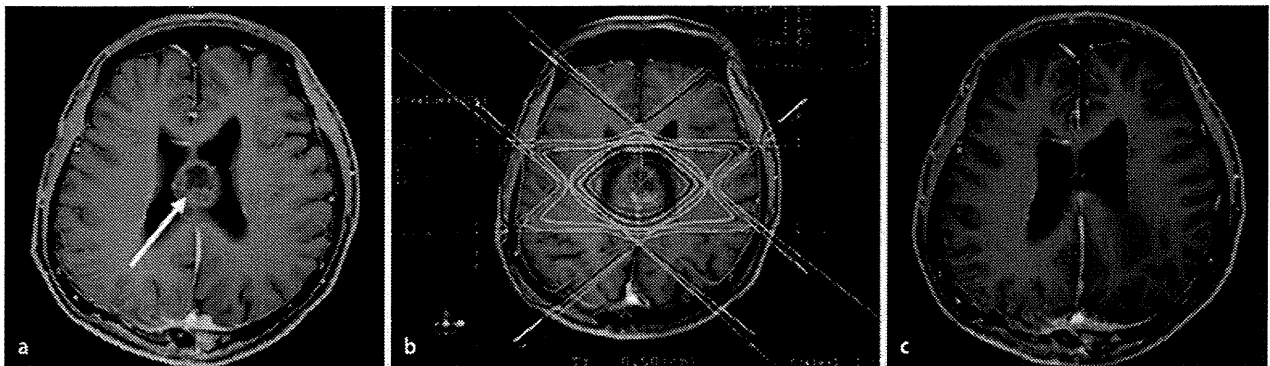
▲ Imaging for a patient treated with reirradiation with conventional RT. a Postcontrast T1-weighted MRI before reirradiation. b Isodose curves for conventional RT representing 100-10% of the prescribed dose at 10% intervals. c Postcontrast T1-weighted MRI at 10 months after reirradiation
